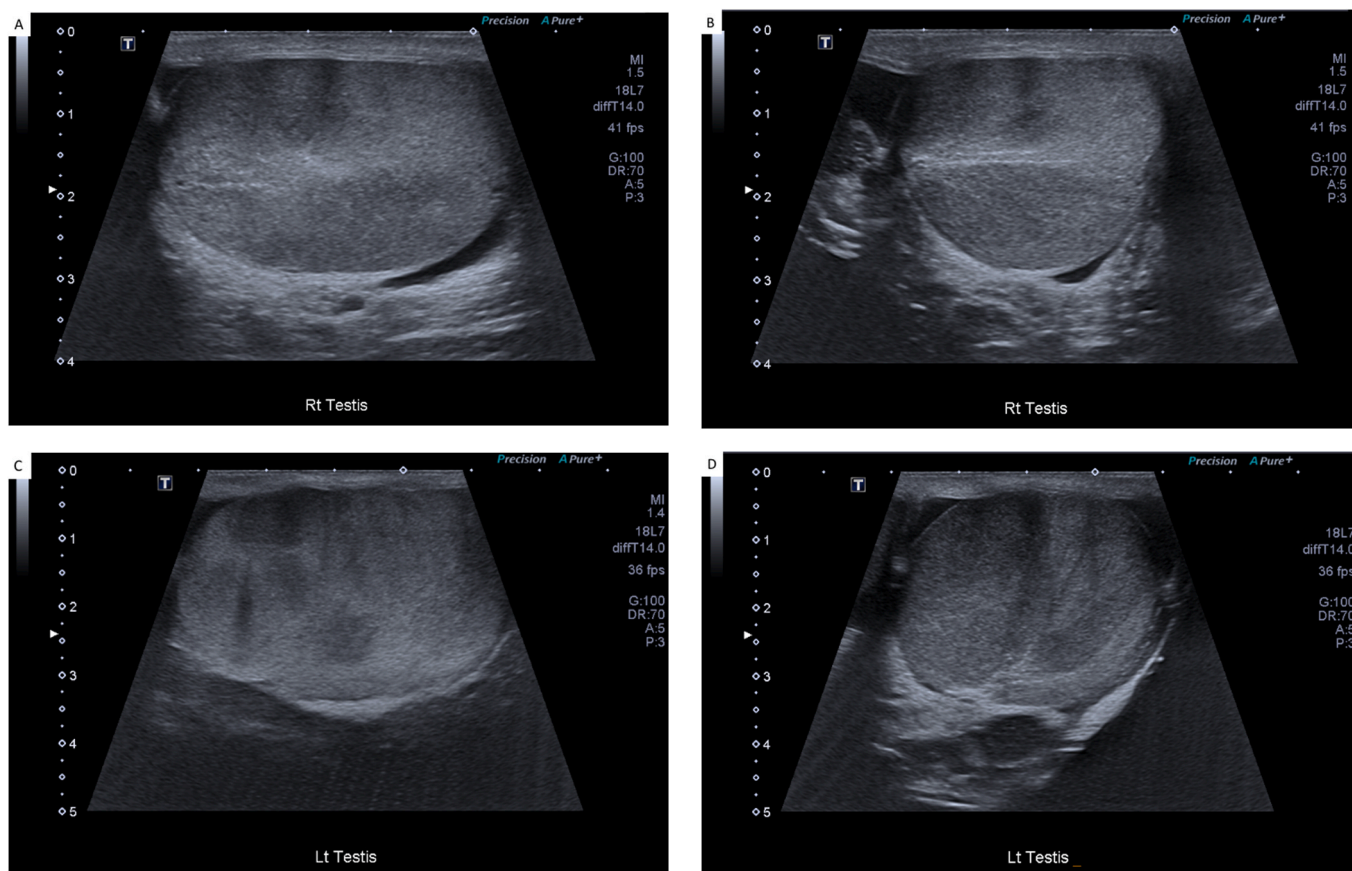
Ultrasound imaging of the testes demonstrating bilateral hypervascular solid infiltrative masses. The right testis in longitudinal (A) and transverse view (B), and the left testis in longitudinal (C) and transverse views (D).
